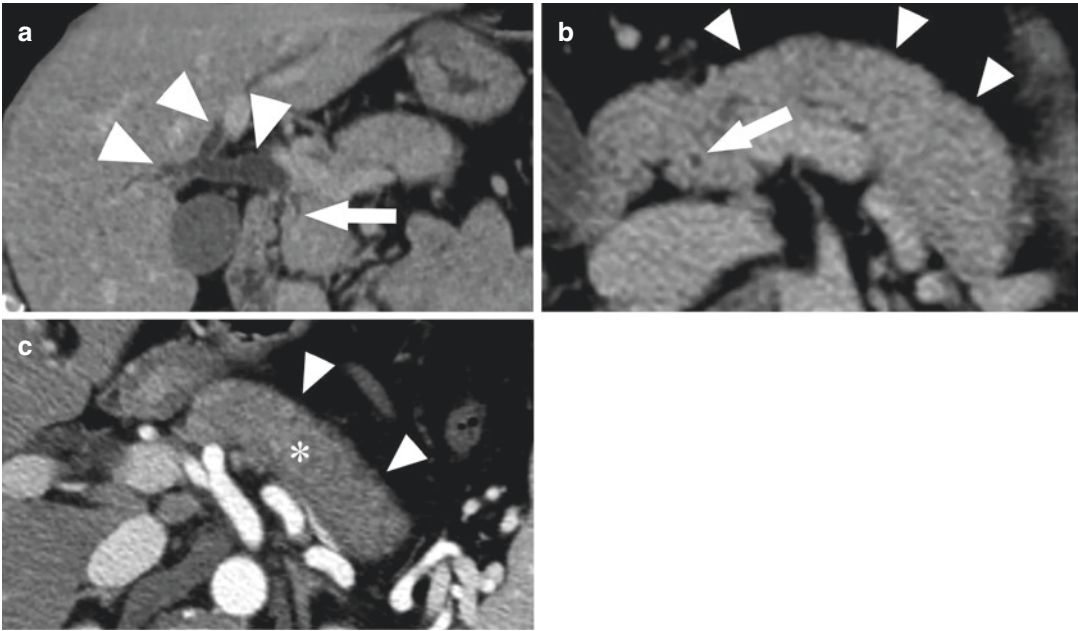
Autoimmune pancreatitis and autoimmune pancreatitis-related cholangitis in a 39-year-old woman. (a) Coronal contrast enhanced portal phase CT image shows smooth and tapered narrowing of the intrapancreatic portion of the distal CBD (arrow) associated with upstream extra- and intrahepatic biliary ductal dilatation with evidence of mild wall enhancement (arrowheads). (b) Axial contrast enhanced portal phase CT image shows
